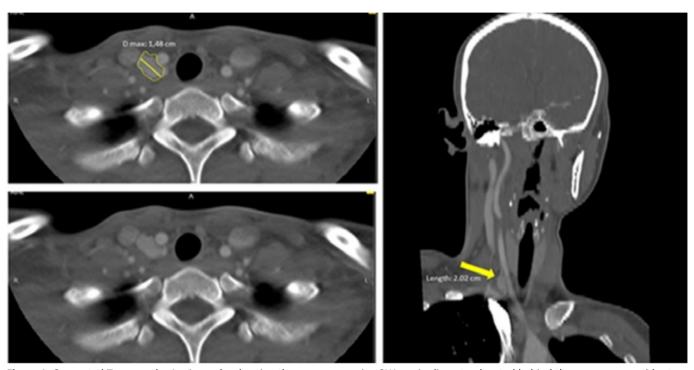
Computed Tomography Angiography showing the mass measuring 2X1 cm in diameter, located behind the common carotid artery and expanding laterally, displacing the internal jugular vein at the level of the sternoclavicular articulation.
